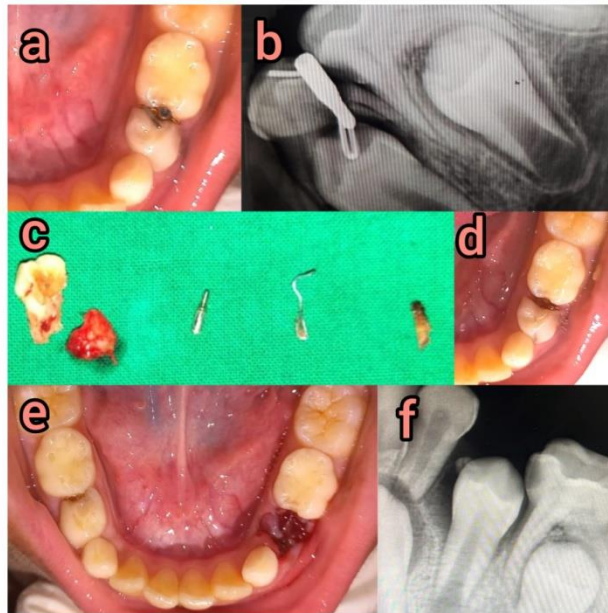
(Case 3) - a: Intra oral photograph i.r.t 74, b: Radiograph of 74 revealing fracture of root due to entrenched foreign objects , c: Retrieved foreign object – pen nib, stapler pin, tooth pick and fractured parts of 74, d: Tooth post retrieval, e: intra oral photograph after extraction of 74, f: radiograph post extraction of 74.
